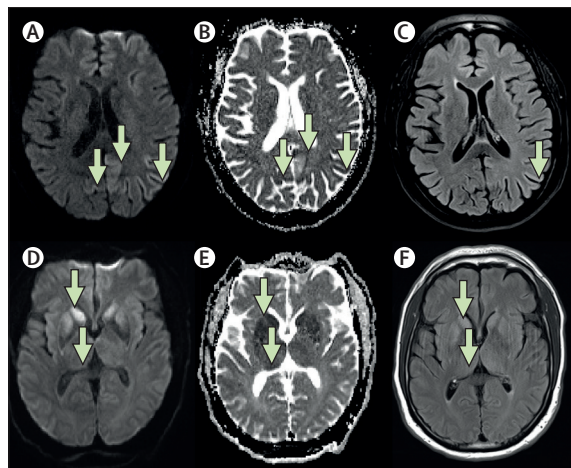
Typical patterns of restricted diffusion on Creutzfeldt-Jakob disease MRI
